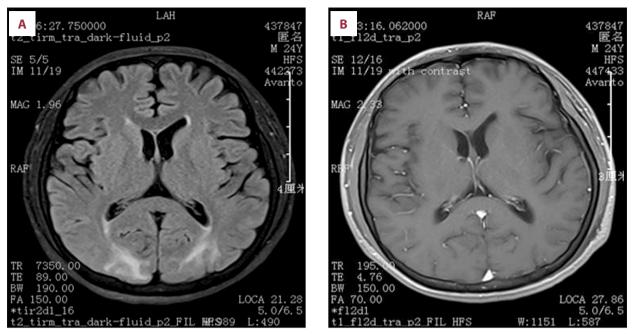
Axial FLAIR image, obtained 5 days after the patient's seizures, reveals high-signal-intensity lesions at many points in the bilateral occipital cortex and posterior parietal cortex (A). Follow-up axial FLAIR image MRI on day 72 shows high signal range reduced compared with the image on day 61 (B).
